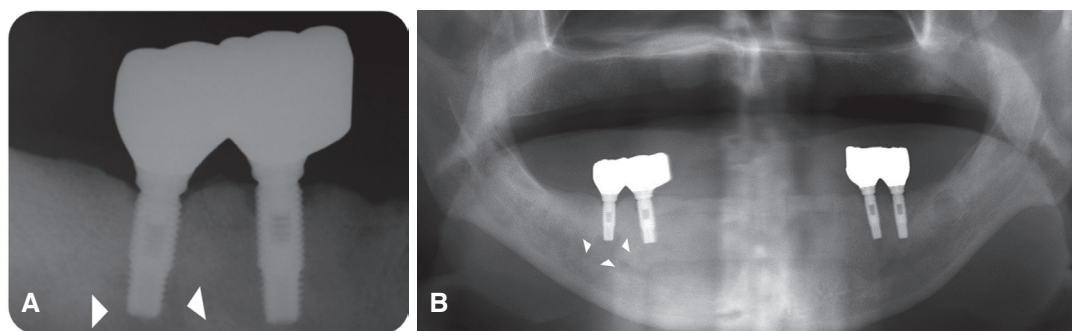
(A) Periapical radiograph of the twelve year-follow up. Although there was neither clinical symptom nor functional problem, the radiolucency has continued to exist, (B) Panorama of the twelve year-follow up taken on the same day of Figure 5A. Arrow heads depict the extent of IPL.
